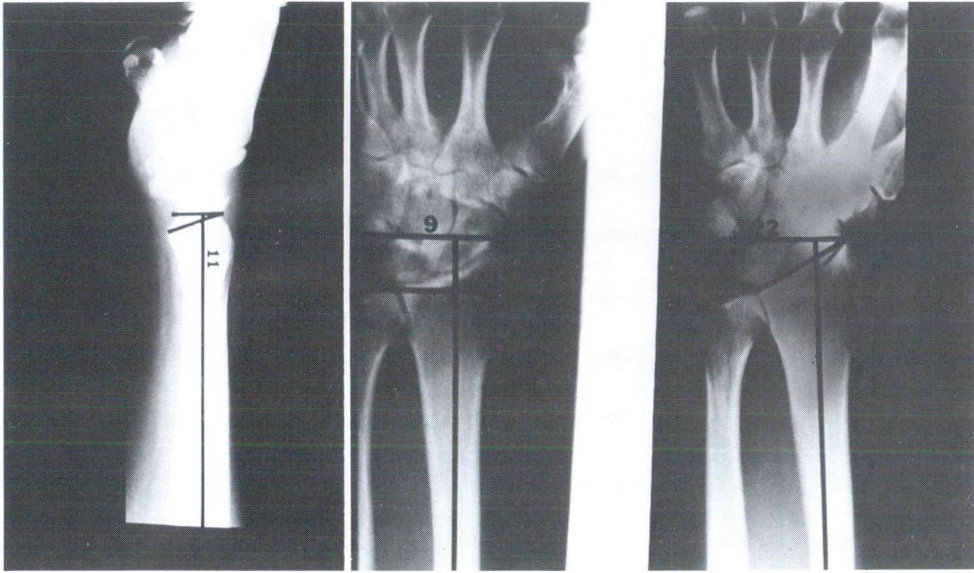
X-Ray measurements utilized.
